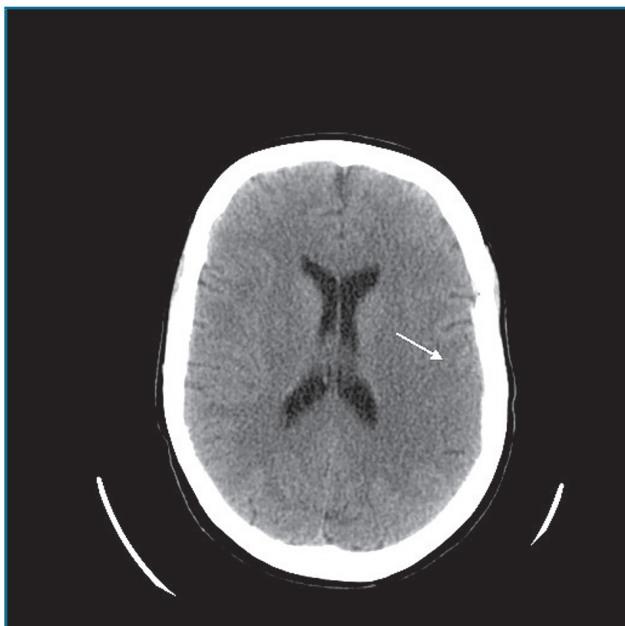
Cranial computed tomography showing contrast attenuation of the left cerebral parenchyma (arrow), an early sign of ischemic stroke.
